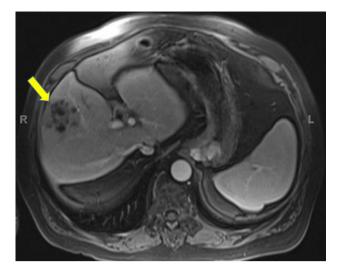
T1-weighted MRI of abdomen during portal venous phase demonstrating a 4.4×5.5 -cm mass in segment V/VI of the liver (*arrow*)
